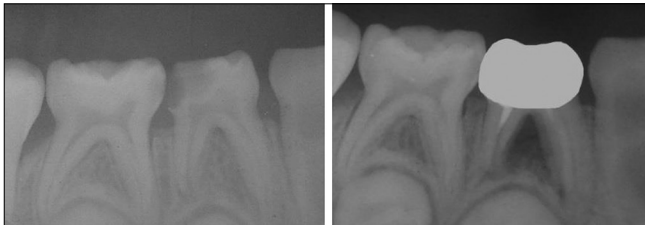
Radiographic features of the teeth treated with formocresol. (a) preoperative radiograph (b) Primary molars showed no changes at 6 months postoperatively
